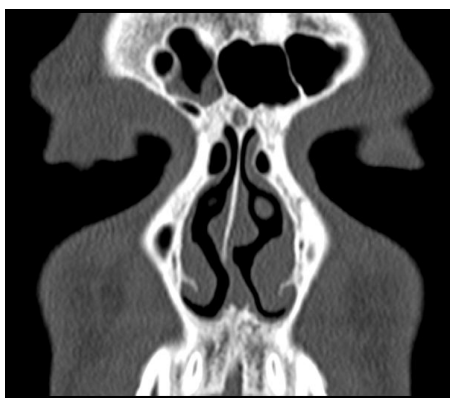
Coronal reconstructed CT scan showing bilateral agger nasi cells.
